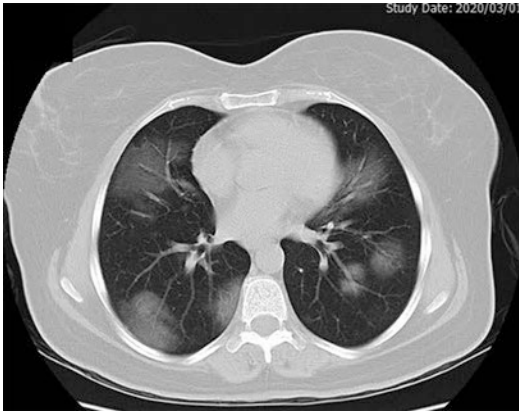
Axial chest CT scan without contrast in a 46-year-old female with COVID-19 pneumonia shows bilateral multifocal patchy ground-glass opacities (GGOs)
